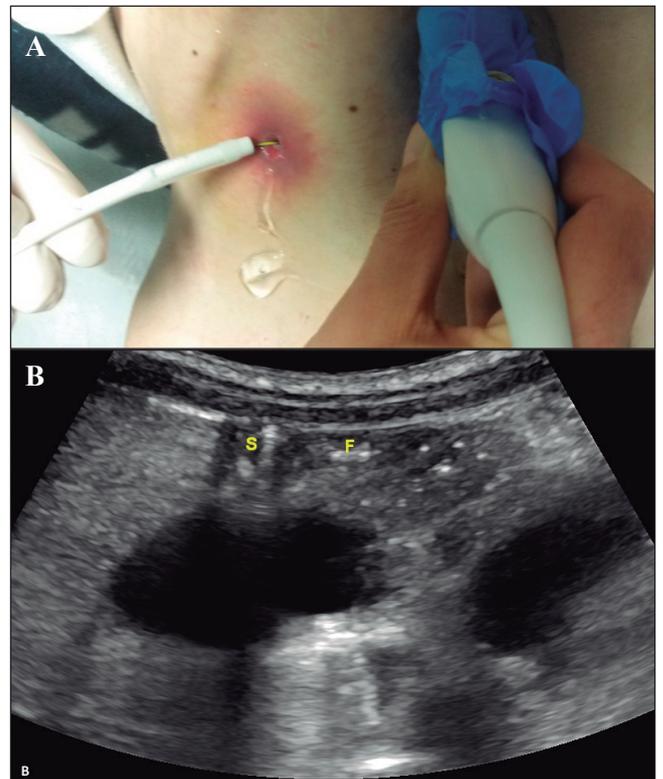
A. Gentle advance of the balloon-tube over the guide-wire. B. Ultrasound imaging confirming the adequate advance of the balloon-tube ("S") over the guide-wire ("F") into the jejunal lumen.
